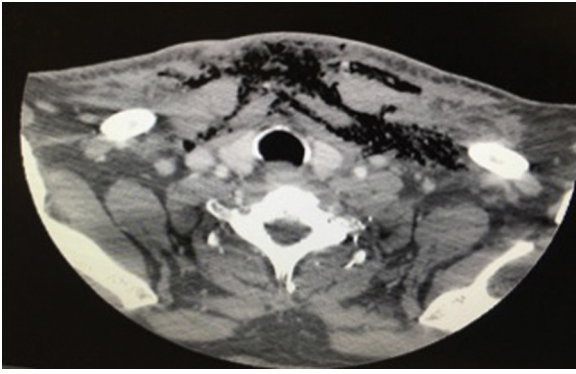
CT showing air dissecting into the anterior mediastinum.
